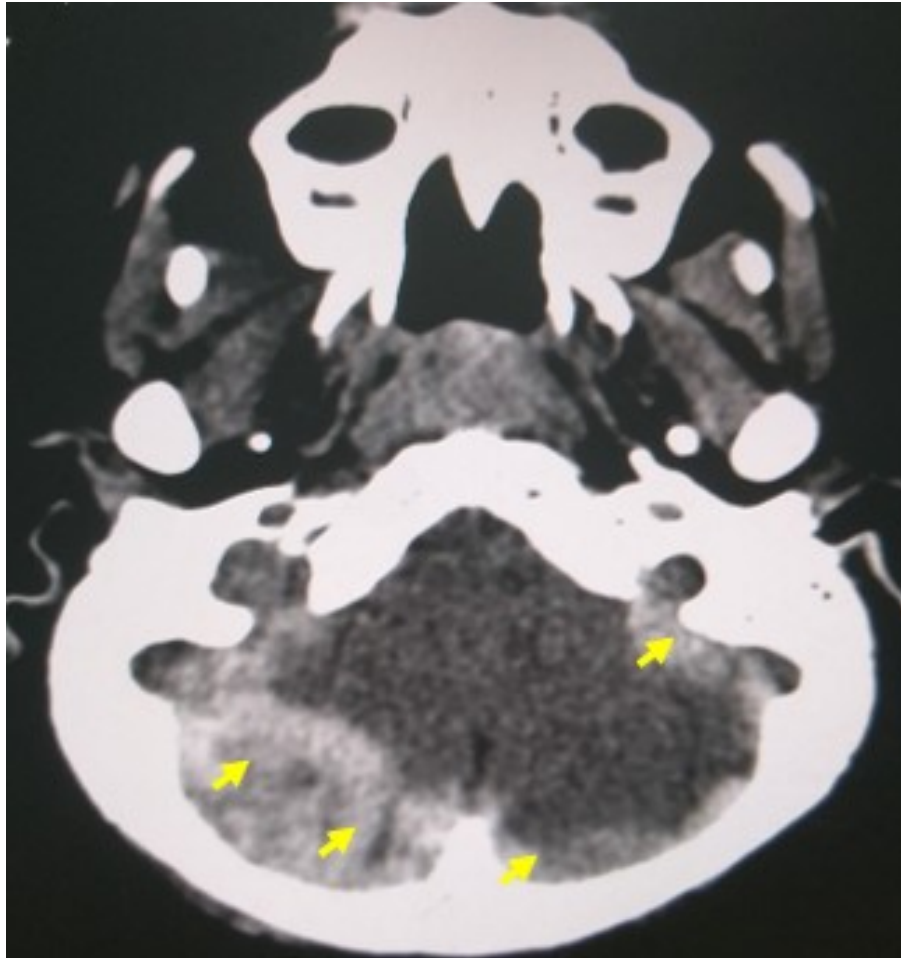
CT axial section: Posterior fossa haematoma, more marked on the right (yellow arrow)
